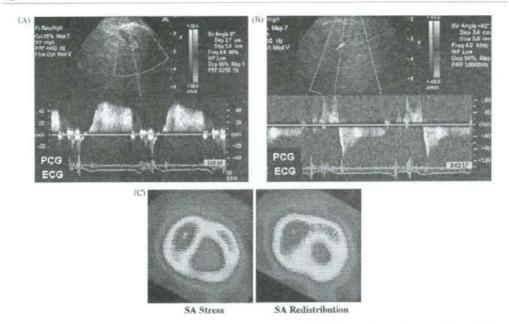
Fifty-three-year-old female with a history of syncope. Transthoracic Doppler echocardiographic measurement of left anterior descending coronary artery (A) and intramyocardial coronary artery (B). The pulsed Doppler echocardiography in the intramyocardial coronary artery demonstrating characteristic no reflow-like pattern, so we classified this patient into group B. (C) Thallium-201 scintigraphy showing abnormal perfusion with reversible ischemia in the anteroseptal segments.
